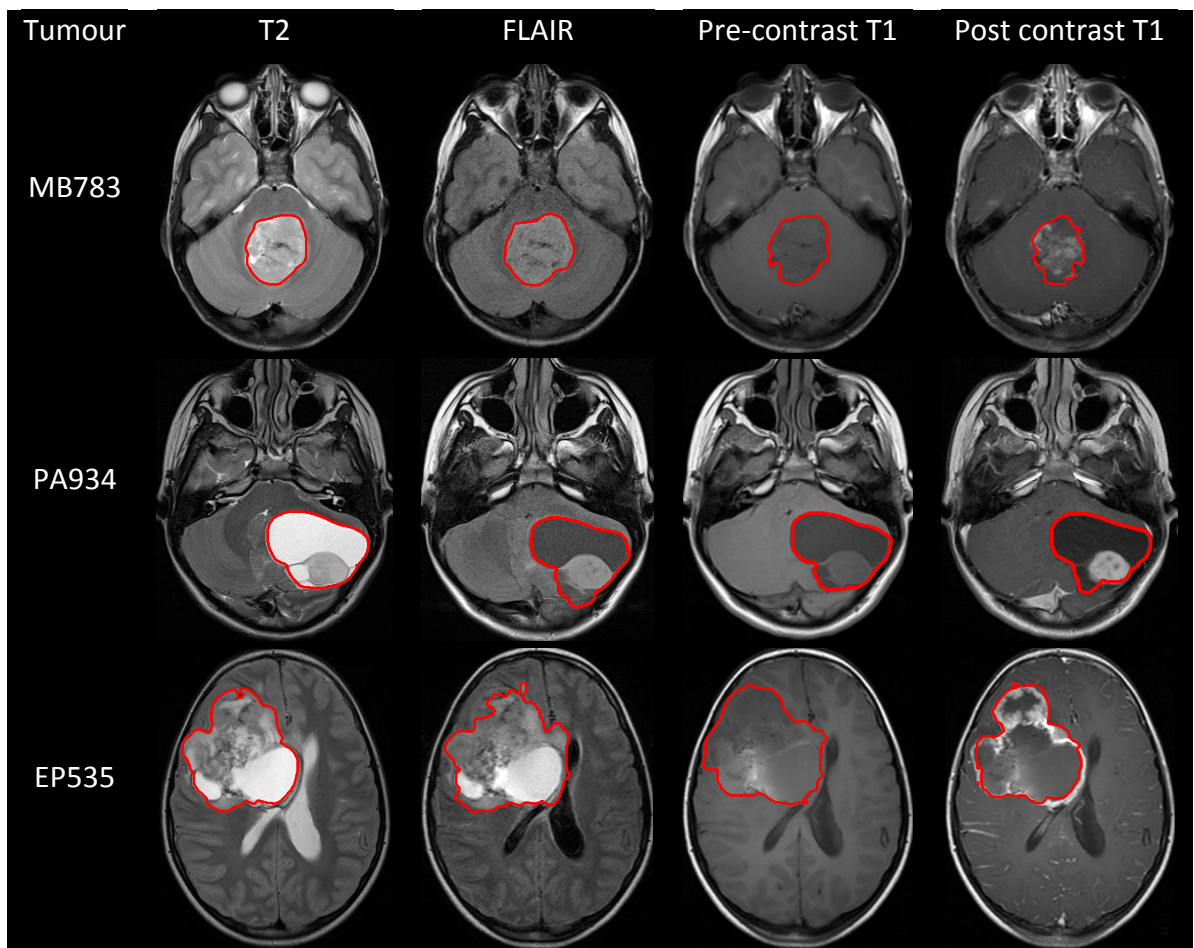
Semi-automatic segments of medulloblastoma, pilocytic astrocytoma, and ependymoma based on T2, FLAIR, pre-contrast T1, and post-contrast T1.
